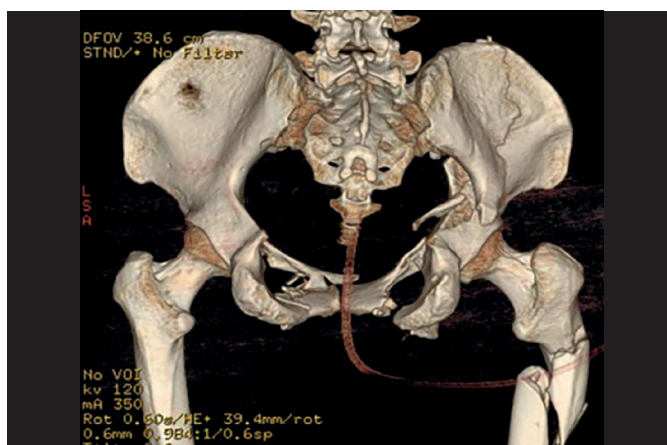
Female, 51 years old, pelvic fracture caused by falling from the high place, posteroanterior position showed by three dimensional rebuild CT image before surgery.
